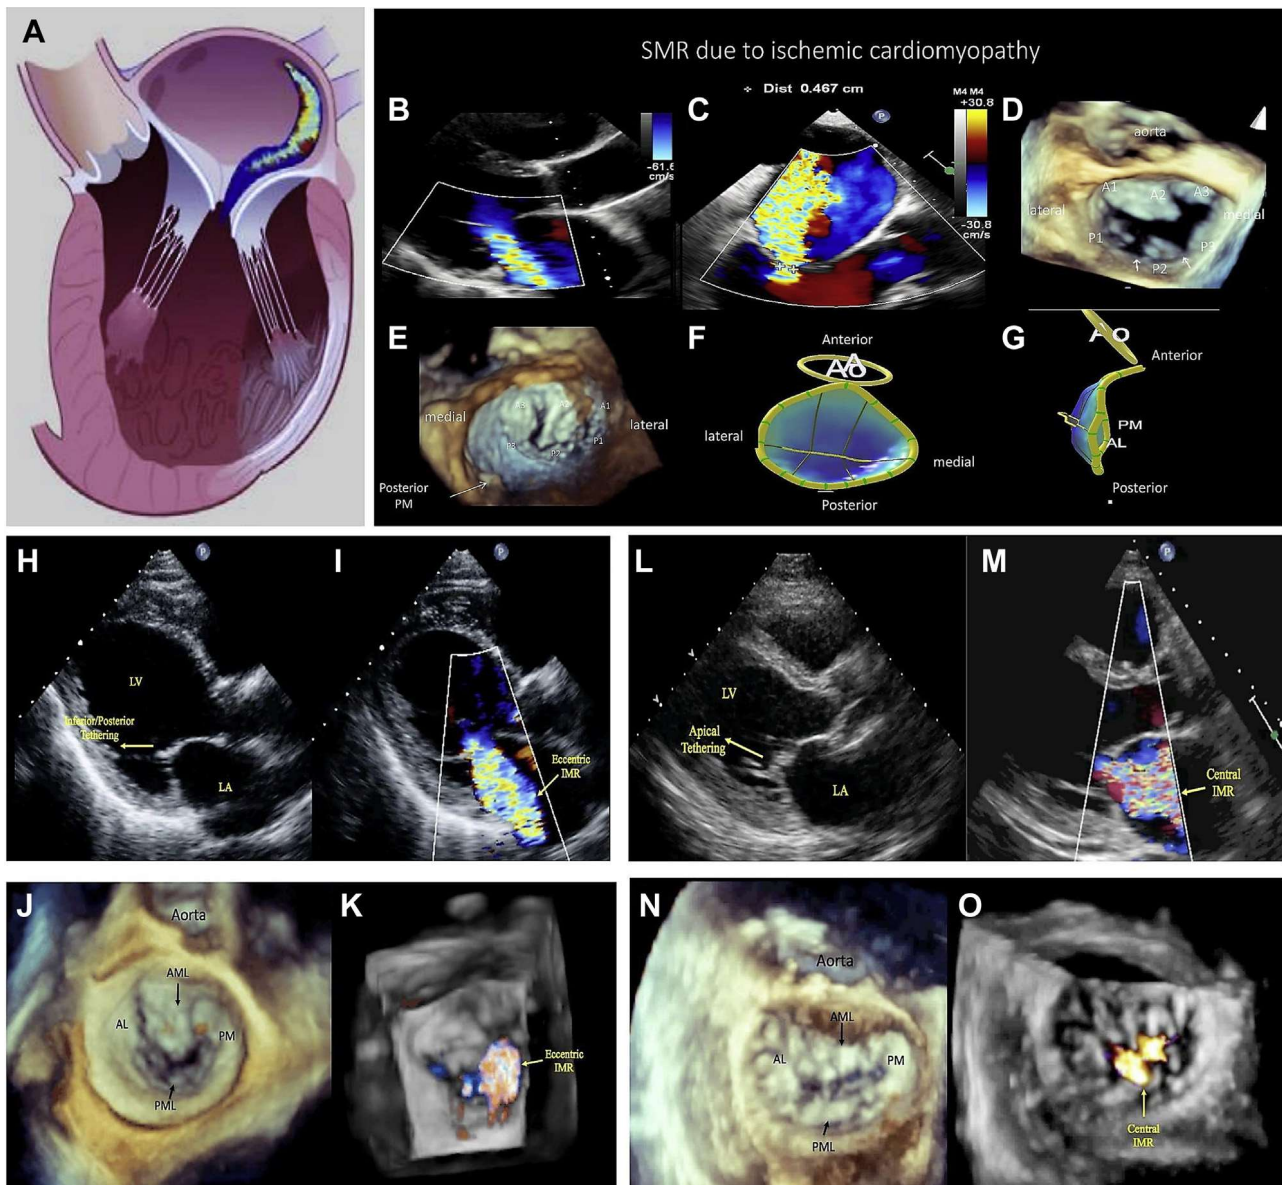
(A) Carpentier type IIIb represents restricted leaflet motion in systole. (B-G) Multimodality echocardiographic imaging for ischemic mitral regurgitation (IMR). (B) Transthoracic echocardiography parasternal long-axis view and (C) transesophageal echocardiography (TEE) left ventricular outflow tract view show eccentric jet of MR due to asymmetrical tethering. (D) Three-dimensional (3D) TEE (en face view from left atrium) shows marked indentations between P2-P3 and P2-P1 (white arrow) due to left ventricular remodeling. (E) 3D TEE (en face view from left ventricle) shows an apical and posterior secondary displacement of posterior papillary muscle (white arrow). (F, G) Reconstruction and model of the mitral valve shows the malcoaptation of mitral leaflets due to a tethering of the posterior valve. (H-K) Asymmetric pattern of mitral valve tethering on 2D and 3D echocardiography in the inferior/posterior direction (yellow arrow) results in posteriorly-directed eccentric ischemic mitral regurgitation (IMR). (L-O) Symmetric pattern of mitral valve tethering on two- and three-dimensional echocardiography. Note central IMR jet. (AL, anterolateral; AML, anterior mitral leaflet; LA, left atrium; LV, left ventricle; PM, posteromedial.)
